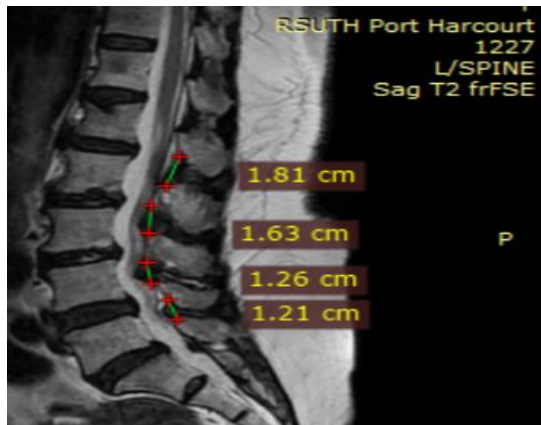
Sagittal T2W MRI showing a close approximation of the spinous processes(kissingspine). Note the close approximation of L3-L4 and L4-L5 spinal levels in BD relative to other lumbar spinal levels without BD.
